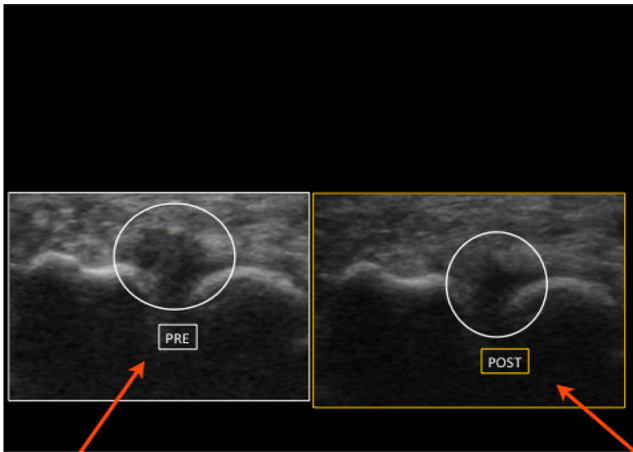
Ultrasound examination of the pre- and postoperative neuroma after six months
